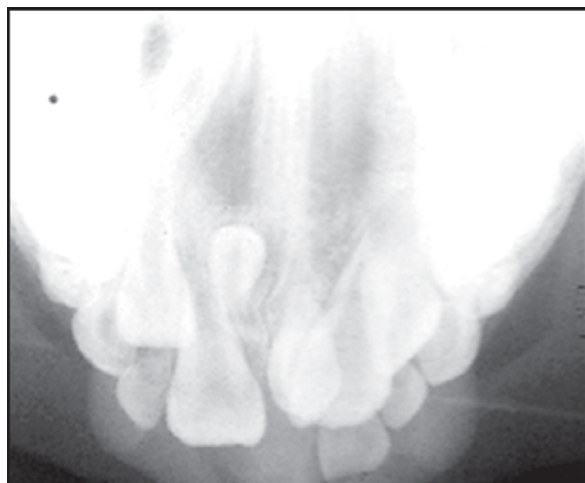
Occlusal radiograph
